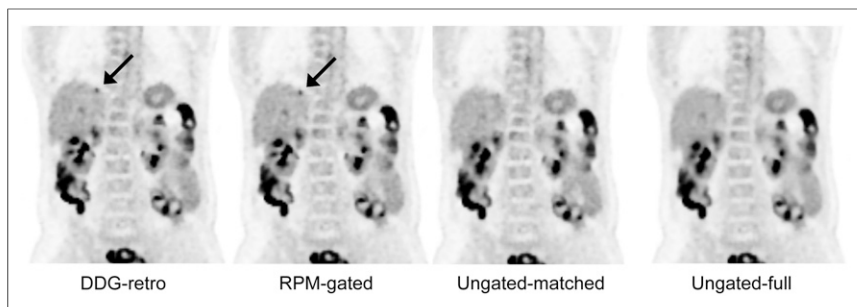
Coronal slices showing ^{18}F -FDG-avid liver metastasis (indicated by arrows) that is easier to detect and has higher SUV_{max} on 2 gated reconstructions than without gating. In this example, DDG-retro and RPM-gated images received equal score for overall image quality, and both were considered superior to ungated images. Lesion indicated by arrow was not considered to be definitely visible on ungated-matched image and was borderline-visible on ungated-full image. One can also see reduction in noise in ungated-full image, as compared with other 3 images. Images are on SUV grayscale of 0–6.
